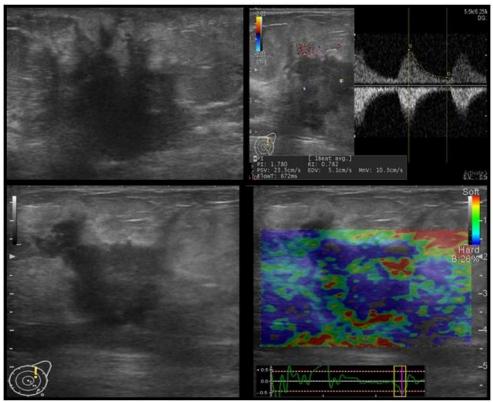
Carcinoma Breast. On B-Mode showed an ill-defined lesion heterogeneously hypoechoic lesion with spiculated margins and posterior acoustic shadowing(Left Upper corner), Doppler images showed both central and peripheral vascularity with peak systolic velocity (right upper corner), Elastography showed the hypoechoic lesion and surrounding area to be hard suggestive of malignant etiology (Right Lower Corner).
